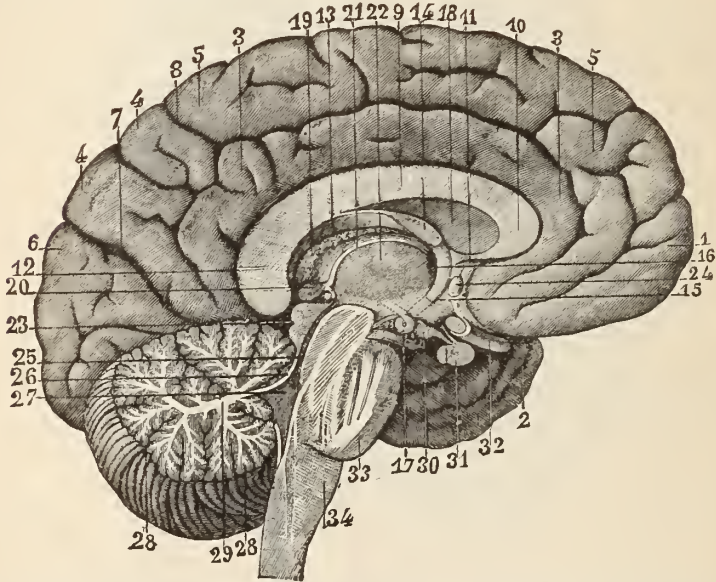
CONVOLUTIONS ON THE INTERNAL ASPECT OF THE HEMISPHERES. (Sappey.)
